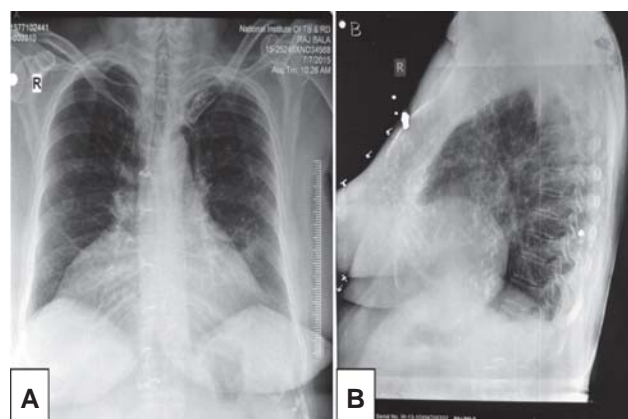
Chest radiograph (A) (postero-anterior view) showing mass like opacity in the right paracardiac region and (B) (right lateral view) showing anteriorly placed rounded opacity.
